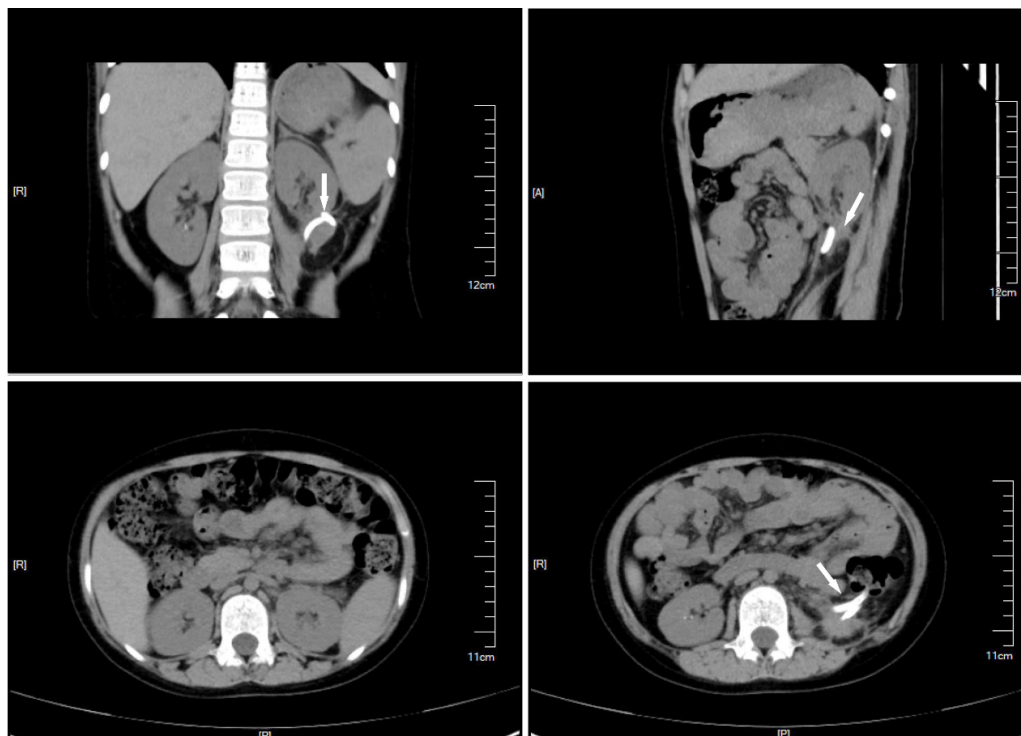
The kidney CT scan in follow up after 2 months. The structure was basically restored, and soft tissue density was seen in the lower pole of the left kidney. The arrow indicates the drainage tube.
